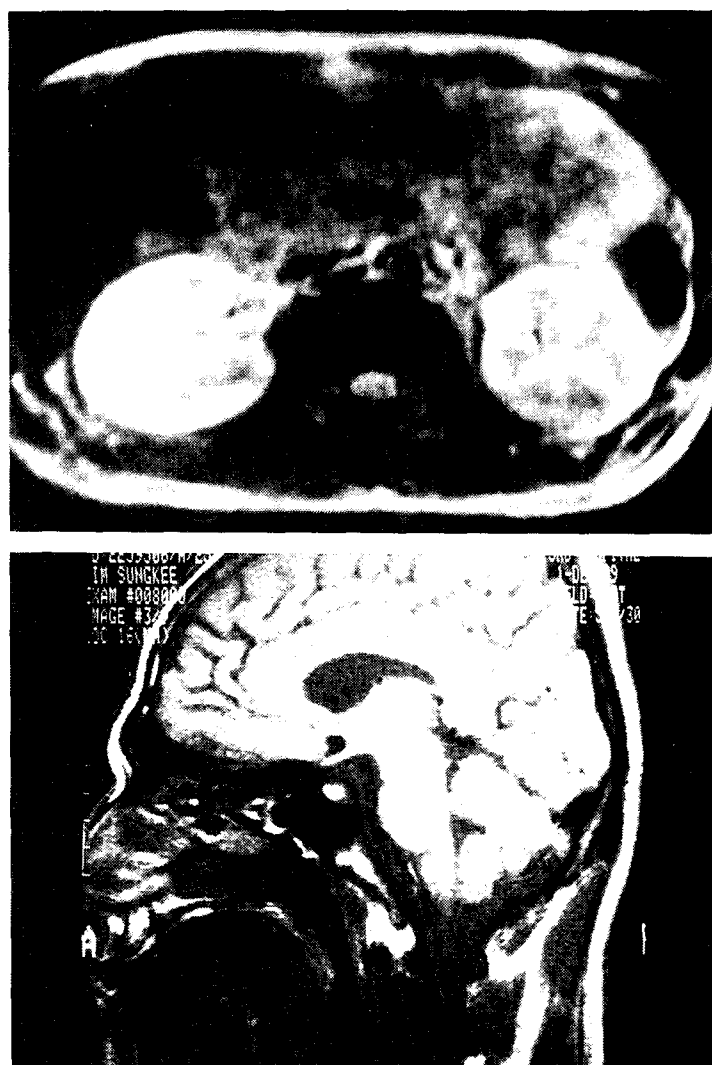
The kidney (A) and sellar (B) MRI findings. These figures show low signal intensity in the renal medulla, and high signal intensity suggesting hemorrhage in the anterior pituitary gland.
